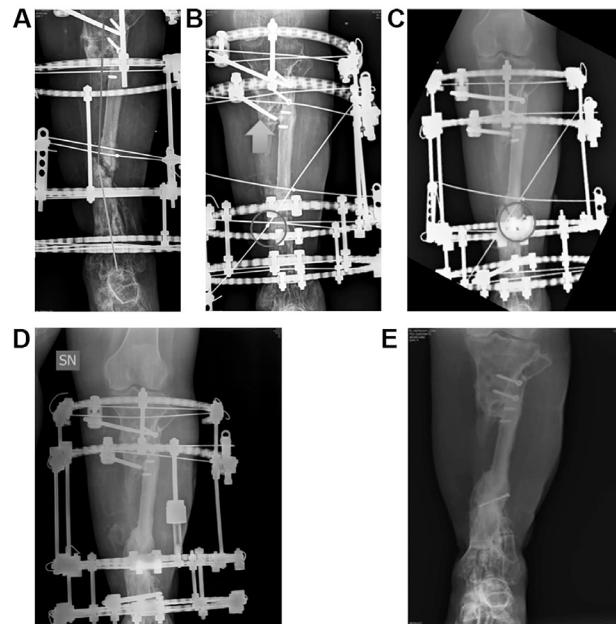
A). The X-rays show a valgus deformity of the distal part of the tibia; B). Reduction of the valgus displacement after the revision surgery with an olive wire pushing the distal part of the tibia; C). A 3.5 mm cannulated screw was used with the aim to reduce the dislocation; D). The last X-ray follow-up with the external fixator showing encouraging bone healing; E): The x-ray control after the removal of external fixator; a satisfying result in terms of stability of the “new tibia” is evident and a complete load was allowed.*
